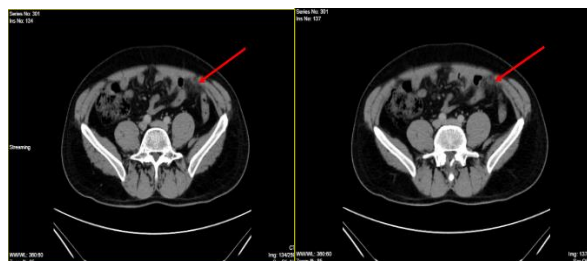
CT images showing a fatty formation in the left iliac fossa with infiltration of the surrounding fat.
